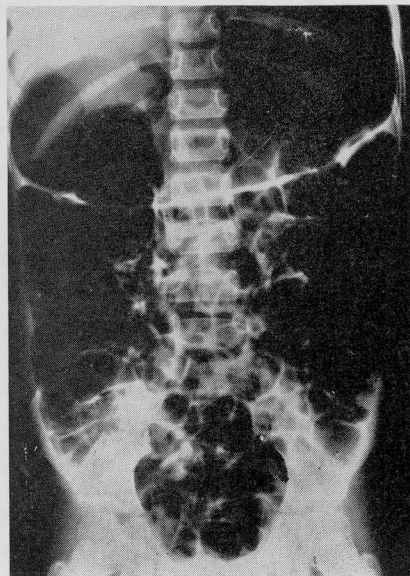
The large amounts of air which may be swallowed in a patient is seen clearly in this X-ray.
